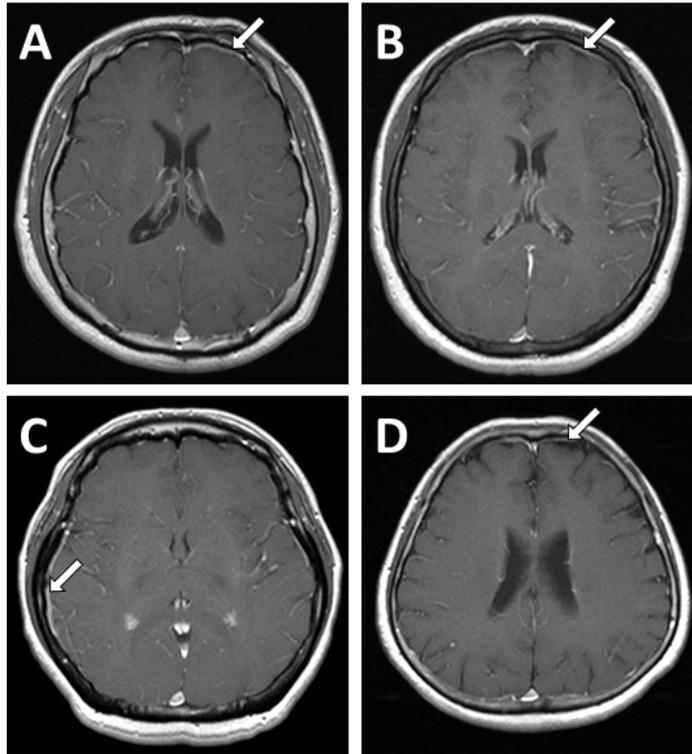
Axial view of the gadolinium-enhanced T1-weighted brain MRI of the four patients, showing pachymeningeal enhancement. (arrows) A. Patient 1; B. Patient 2; C. Patient 3; D. Patient 4.
